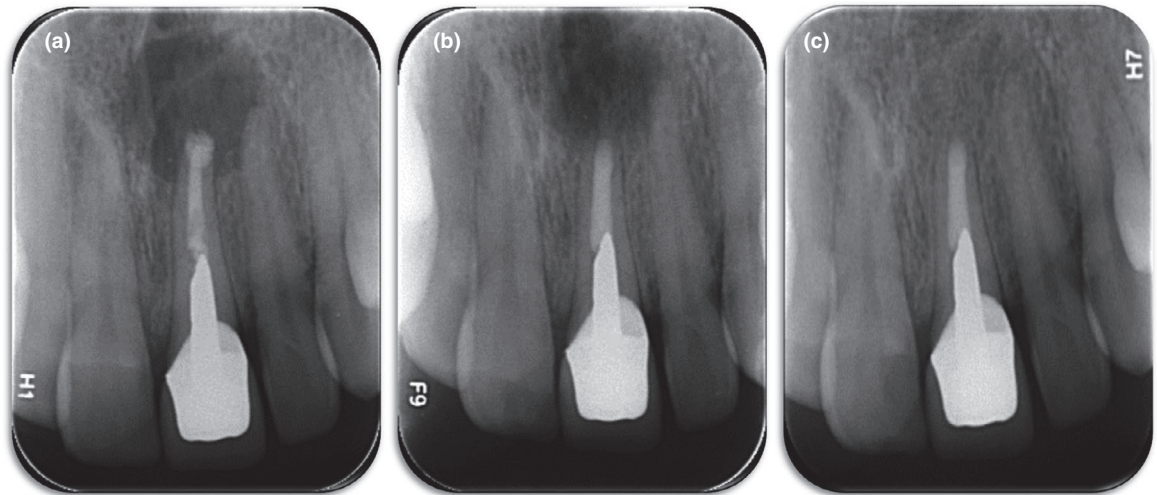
Tooth No. 21—Retrograde root canal retreatment. (a) Preoperative radiograph displays a large periapical lesion and extrusion of root canal filling material. (b) Postoperative radiograph demonstrating a minimal resection and a retrograde retreatment up to the post. (c) 1-year follow-up showing complete healing.
